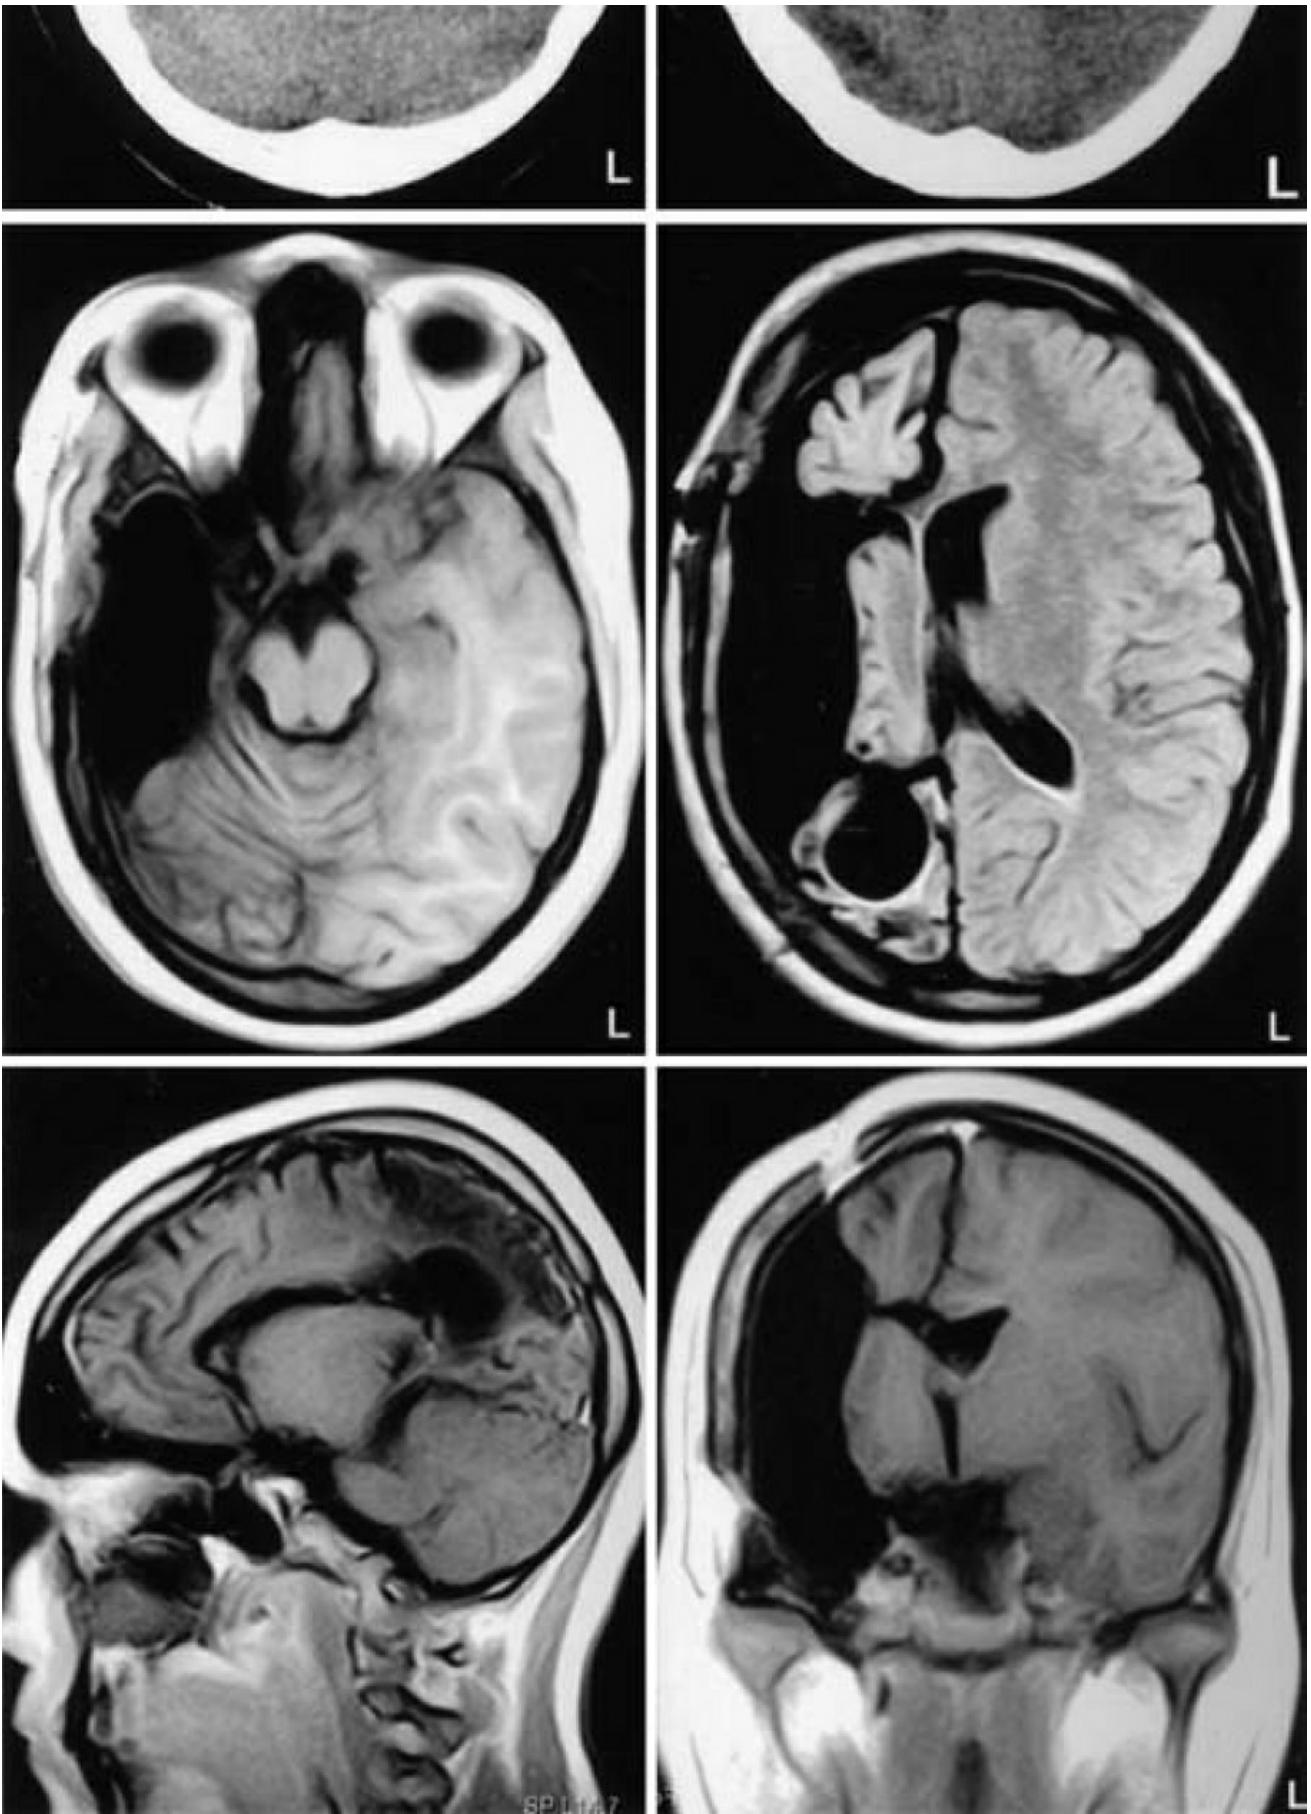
Upper:* Computerized tomography scans obtained 4 hours after surgery. *Center and Lower:* Postoperative MR images obtained 5 months after surgery. (Images courtesy of AL Rhoton, Jr.)
